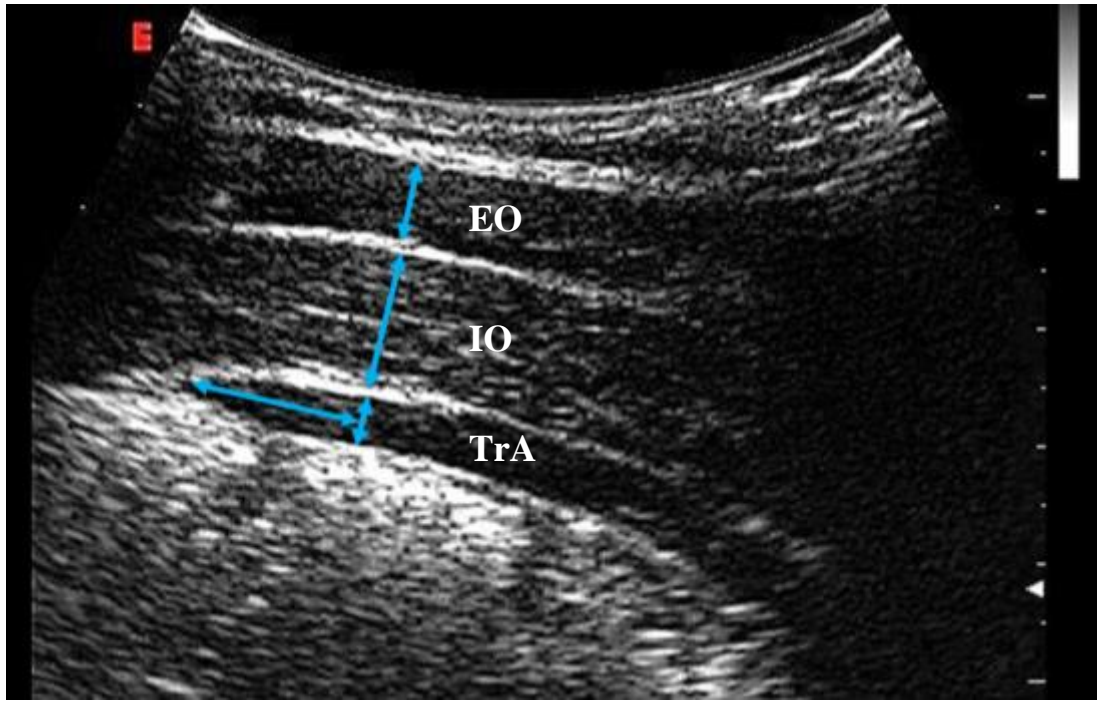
Exemplar captured ultrasound image of the anterolateral abdominal wall including the *external oblique* (EO), *internal oblique* (IO) and the *transversus abdominis* (TrA) muscles. Blue lines denote the standardised distance from the aponeurosis and the orientation of measurement.
